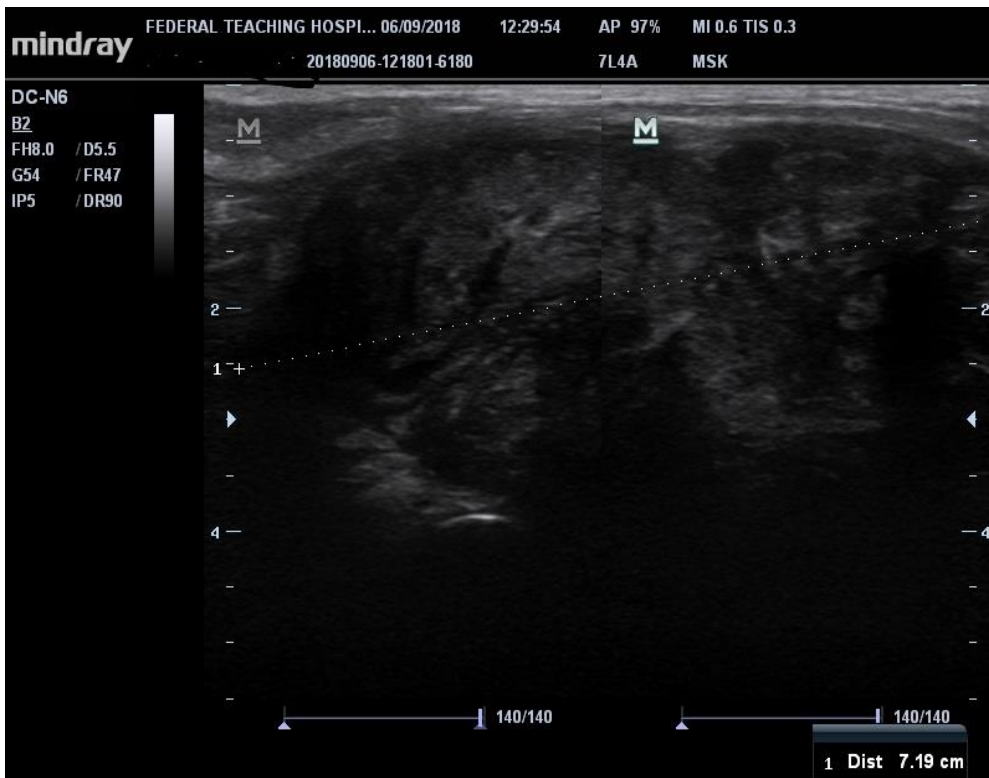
Longitudinal ultrasonographic scan of the left elbow showing a circumscribed mass with heterogenous echotexture.
